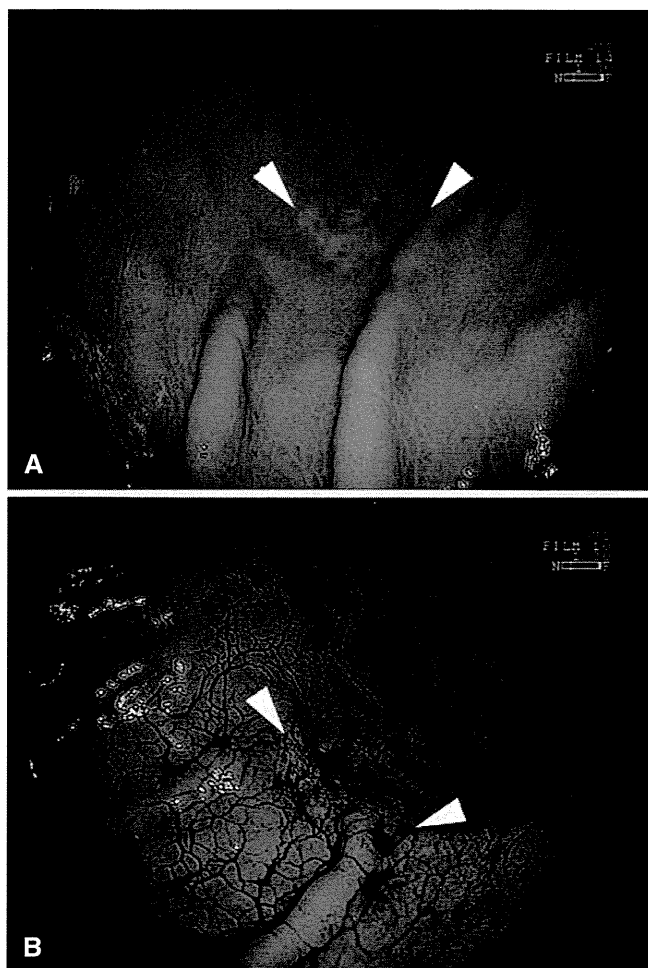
Gastroscopy revealed a depressed lesion in the large curvature of the lower gastric body (*arrowheads*). There were no ulcer findings, and endoscopic ultrasonography showed that this was an intramucosal cancer. A Without dye; B dyeing with indigo carmine
